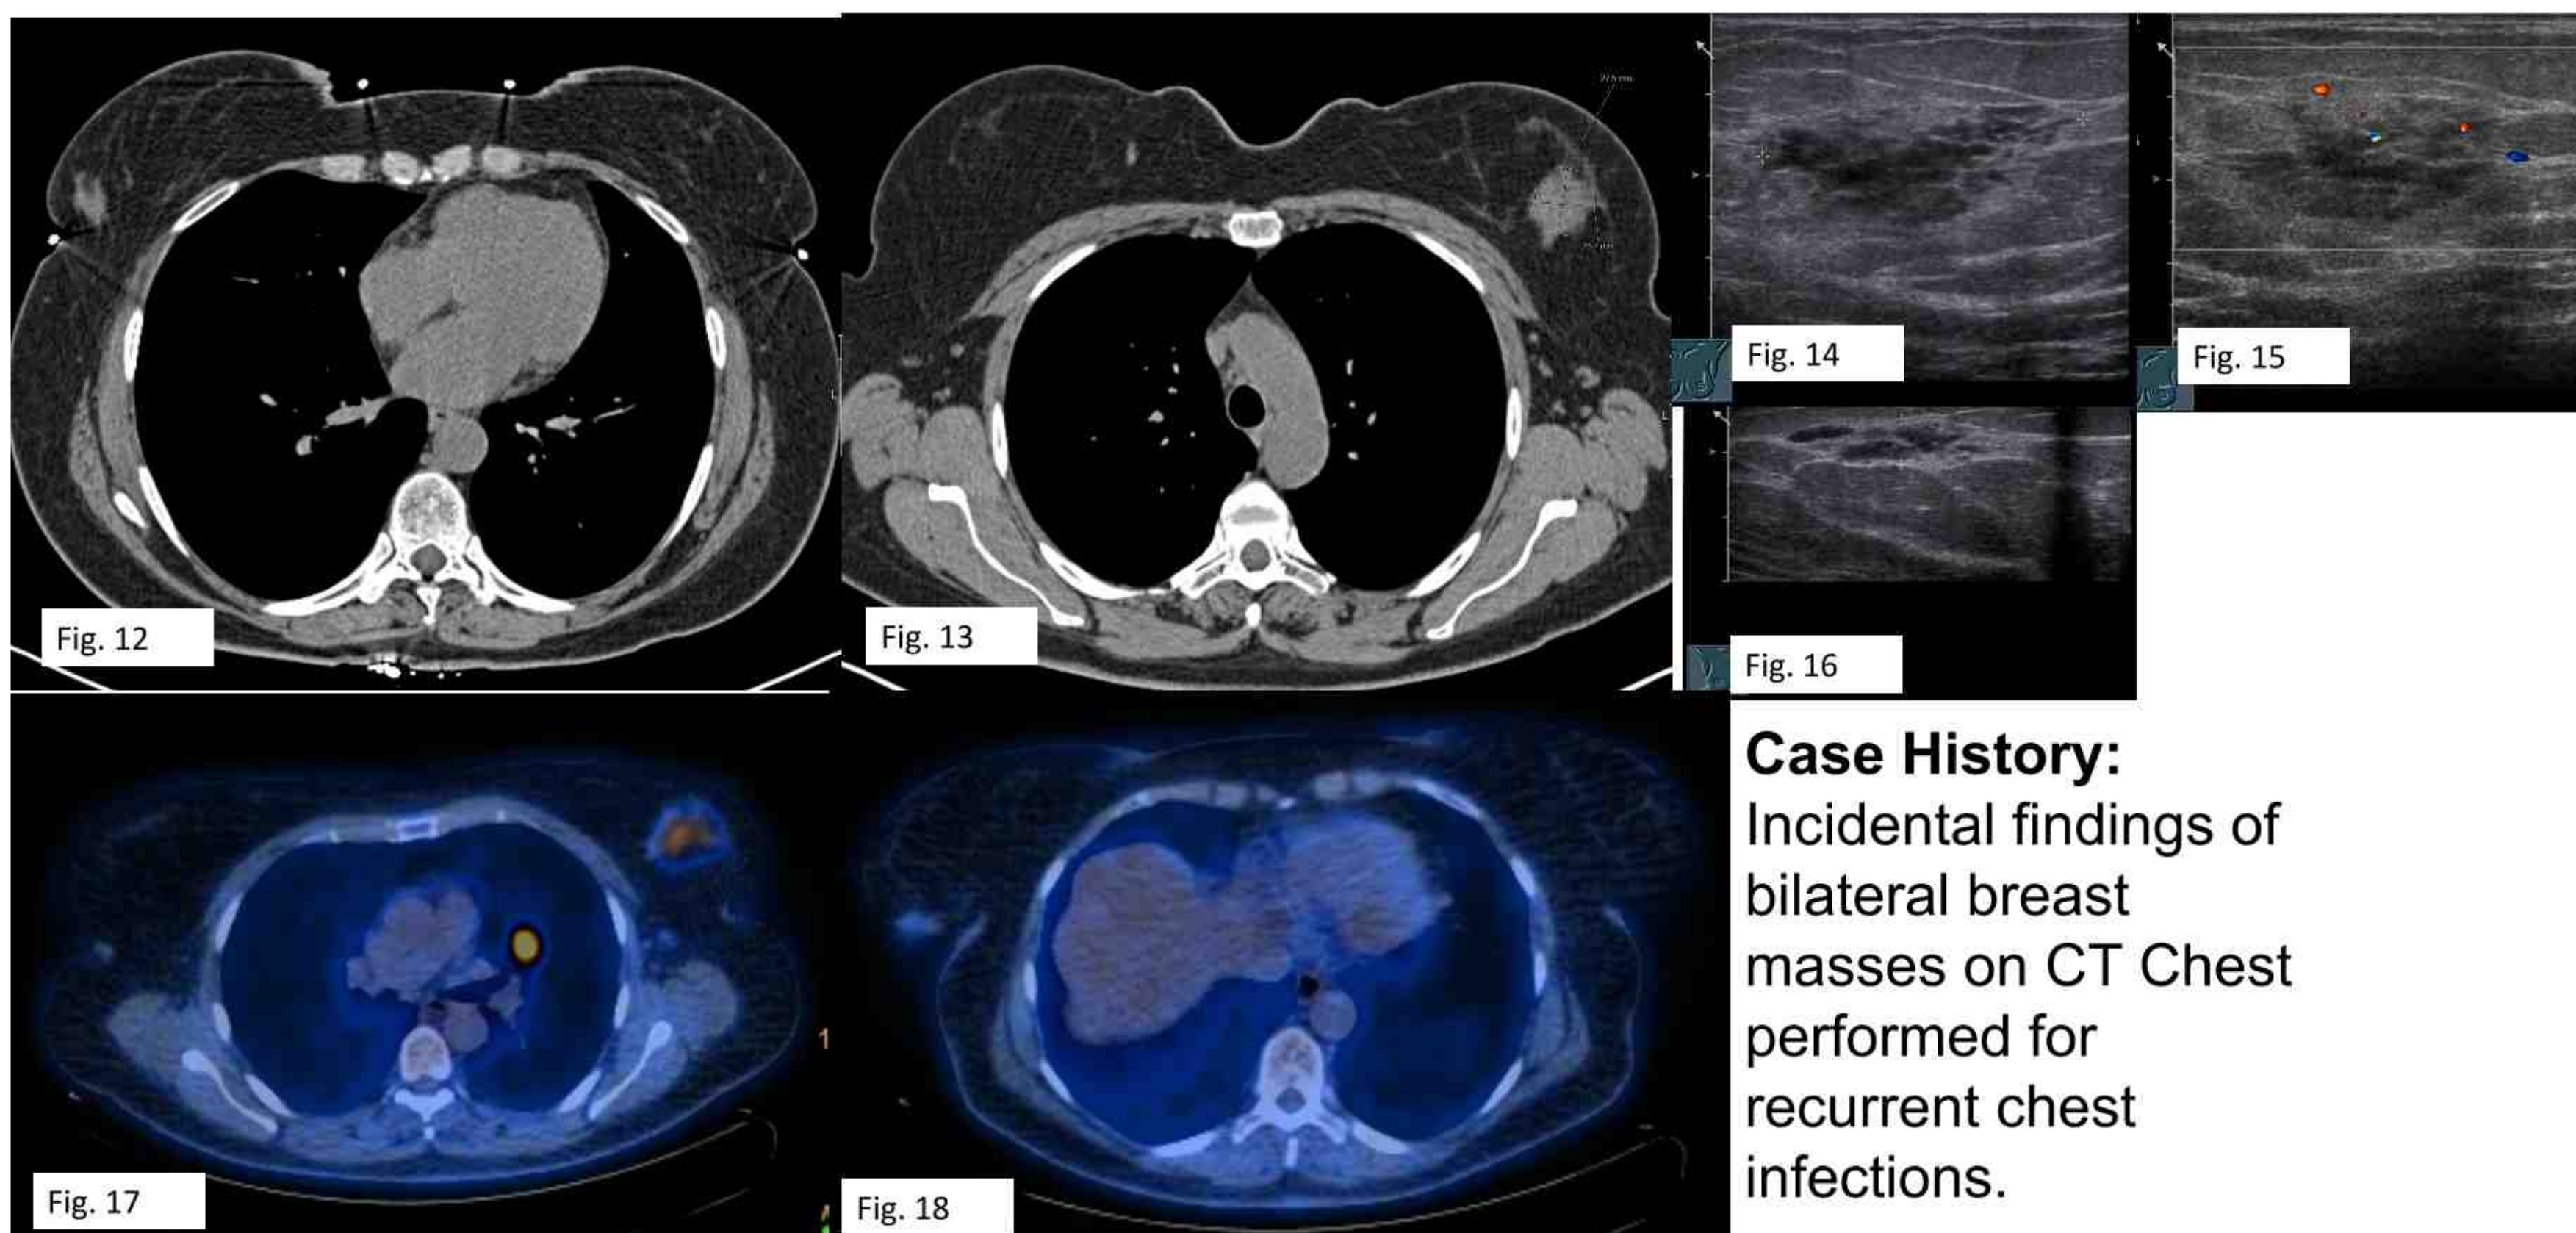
Unenhanced CT Chest: soft tissue masses within the right breast (yellow arrows) corresponding to the US images.
